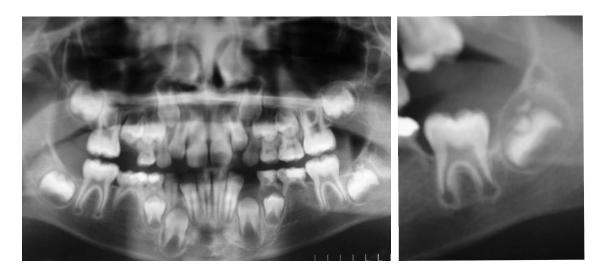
Orthopantomography of the patient. The neoformation is visible over the crown of the left lower second molar germ.
